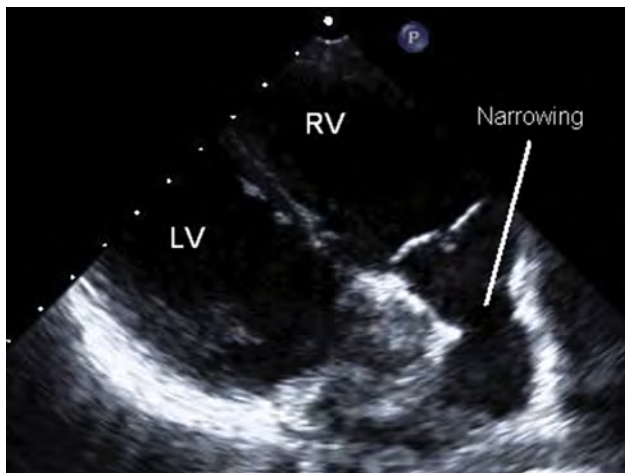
Parasternal long-axis view demonstrates narrowing of the supralvalvar region above the neopulmonary valve after the ASO. *LV*, Left ventricle; *RV*, right ventricle.
